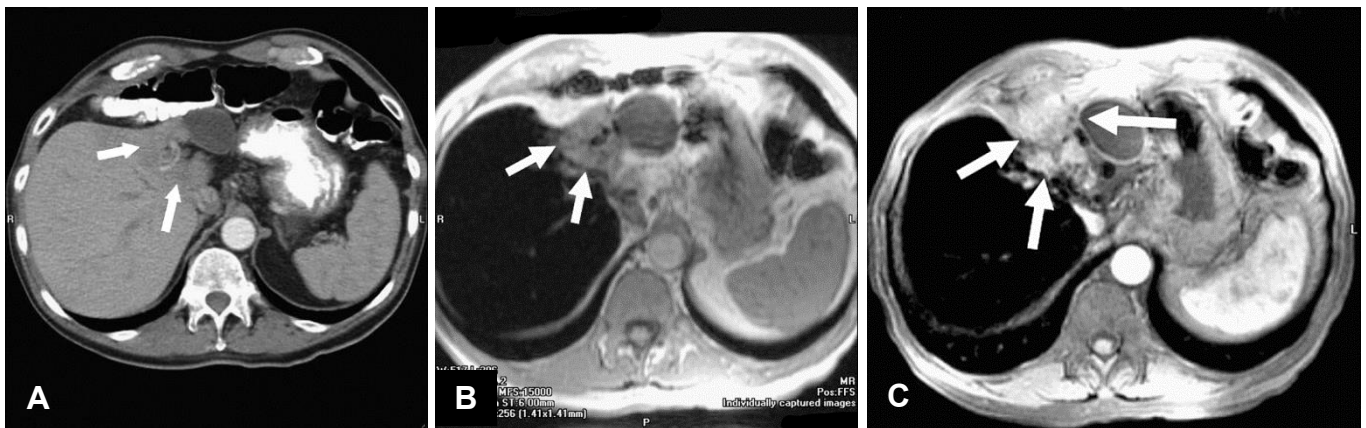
(A) Axial contrast-enhanced liver CT depicts a subtle abnormality of the medial segment of the left lobe of the liver (arrows). (B) Axial precontrast T1-weighted gradient-echo MR image. (C) Postcontrast T1W image. Arrows depict a malignant cholangiocarcinoma.
